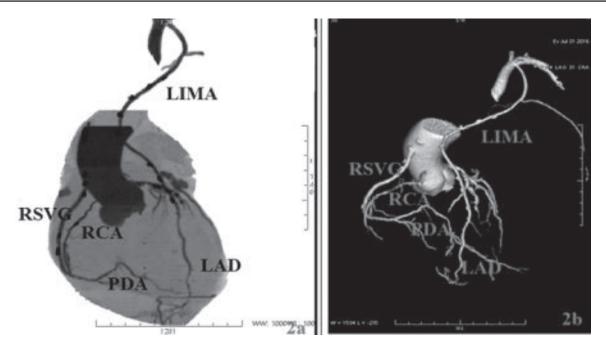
Postoperative CT Angiogram following CE with CABG (2a) and (2b); Patent distal anastomosis graft-LIMA to LAD; RSVG to PDA graft; (A 14cm long atheroma was extracted from RCA of this patient).
